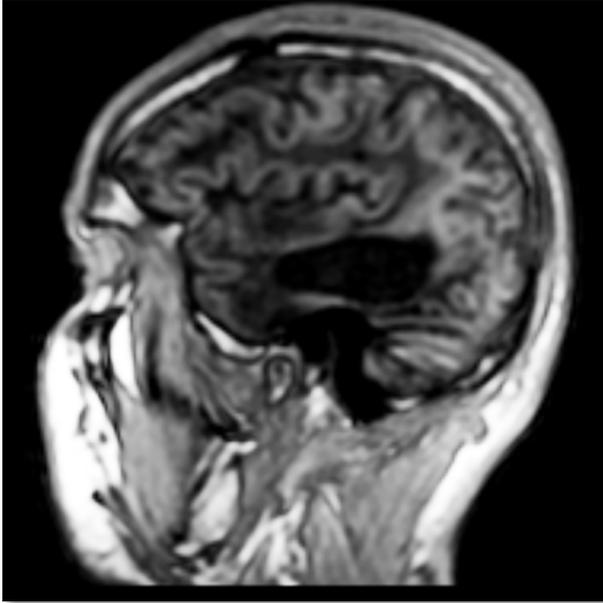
TBI. Cerebral MRI after difusse axonal injury occurred 8 years before. Chronic porencephaly area at the level of the right temporal lobe, with related enlargement of the temporal horn of the right lateral ventricle and signs of chronic break of the blood-brain barrier in practically the entire hemispheric area corresponding to the parieto-temporal region and right frontal. Lacunar infarction at the level of the right striated ganglion. This patient had been treated with an intra-arterial infussion of MSCs ($1 \times 10^6/\text{kg}$) without reaching any significant improvement. At admission in our Center he presented an important loss of recent memory, cognitive deficits, dysarthria, and a complete loss of equilibrium. He was treated with GH, 1 mg/day, 5 days/week, in periods of 3 months each one followed by 1 month without the hormone and neurorehabilitation during 16 months. At discharge only the equilibrium remained affected, but he was able to walk with a walker.
